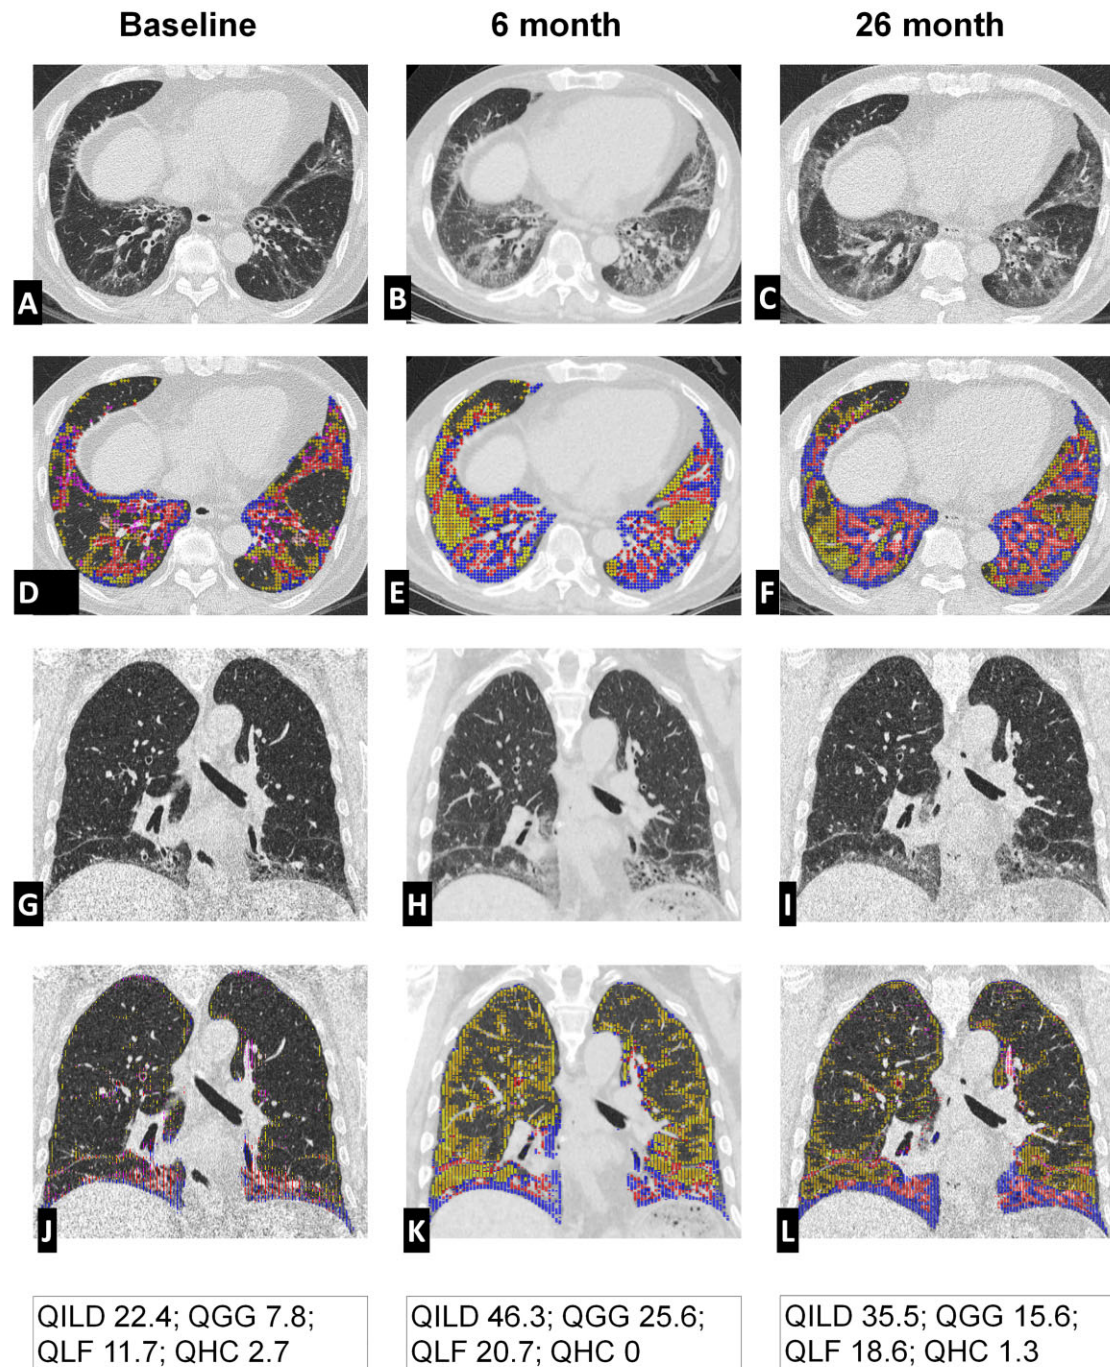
Representative serial images of a 57-year-old male patient with dermatomyositis showing concave-like dynamic QILD scores. Axial HRCT images are displayed consecutively at baseline, 6 months and 26 months (A–C). QILD scores are annotated on the axial images (D–F). Blue dots represent fibrosis, yellow dots represent ground-glass opacities and pink dots represent honeycombs. Coronal views of HRCT images (G–I) and QILD-annotated images (J–L) are also shown. Each QILD score is indicated in the box below. HRCT: high-resolution computed tomography; QGG: quantitative ground-glass opacity; QHC: quantitative honeycombing; QILD: quantitative interstitial lung disease score; QLF: quantitative lung fibrosis
